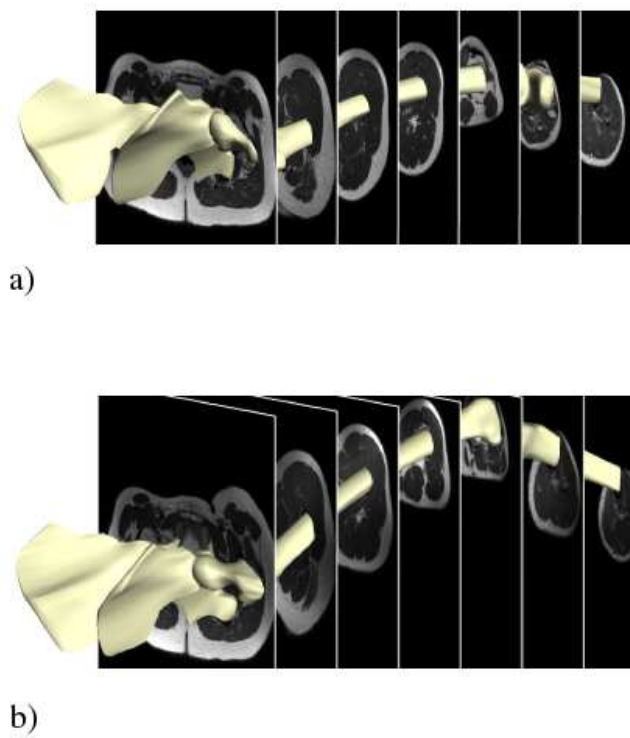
Bone structures were registered in position A and B based on the MRI data. The knee flexion-extension angles were approximately 15° in position A and 45° in position B respectively.
